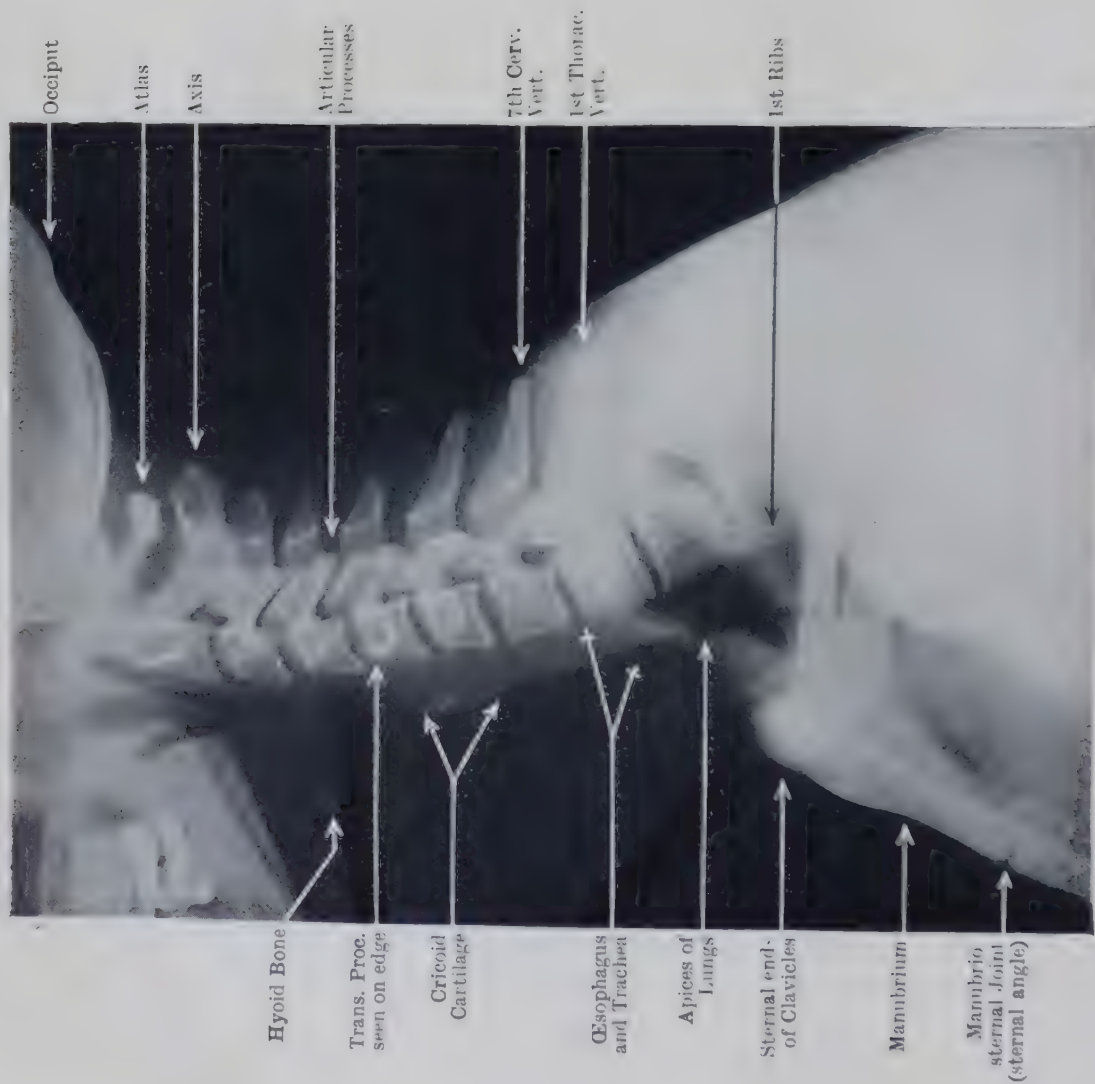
LATERAL RADIOGRAPH OF NECK OF WOMAN AGED 28 TO SHOW THE FORM AND ARTICULATIONS OF THE CERVICAL VERTEBRÆ.
